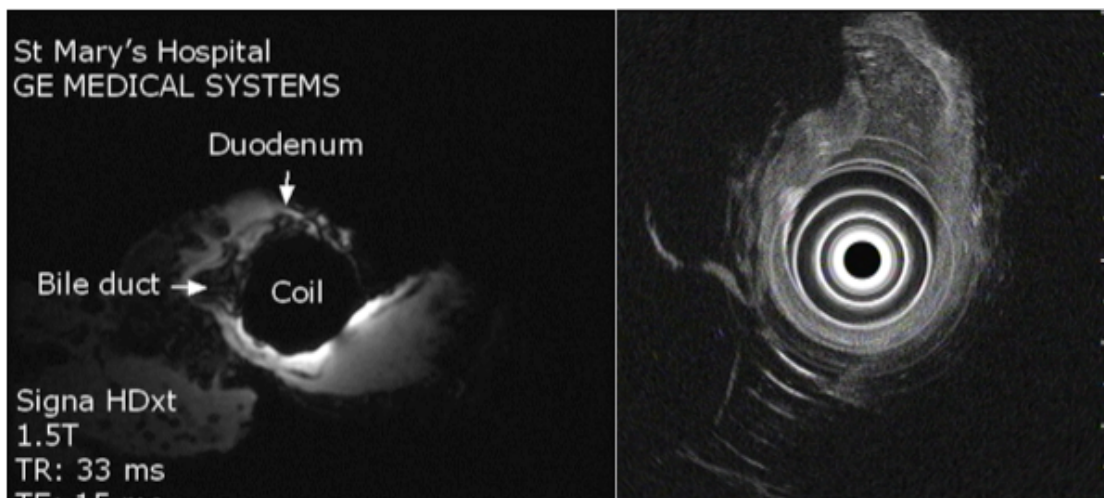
Integration of endoscopic and MR imaging
